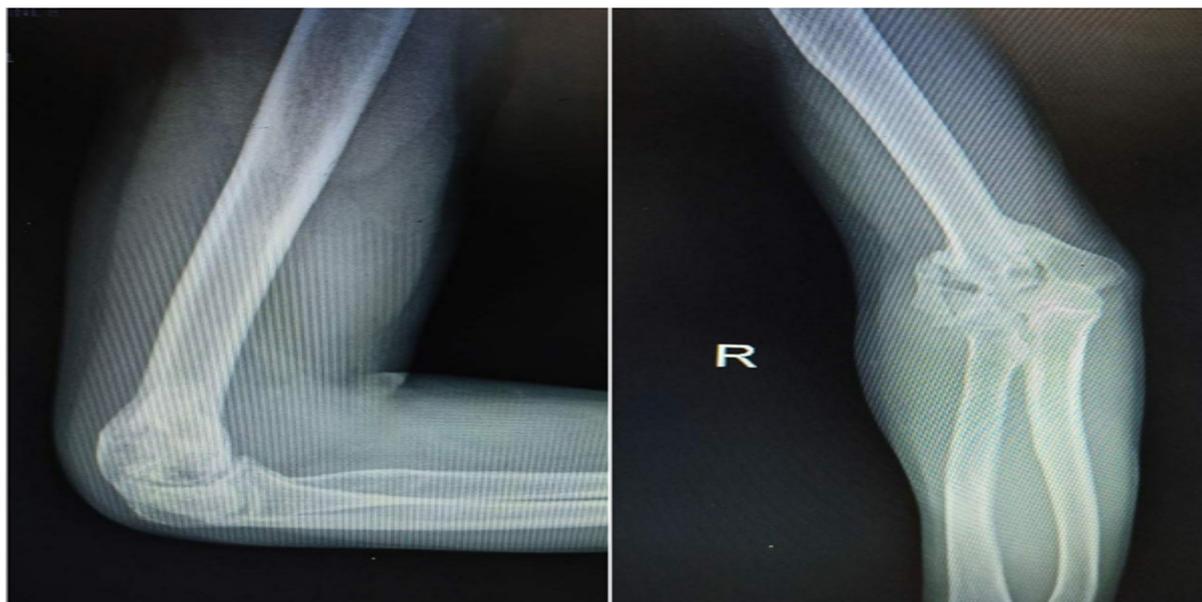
X-rays 3 months after trauma showing the bony union of distal humerus fracture.
